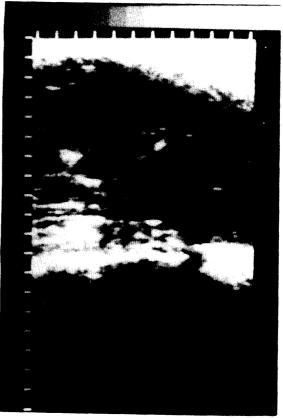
Ultrasonogram of serous cystadenoma.
